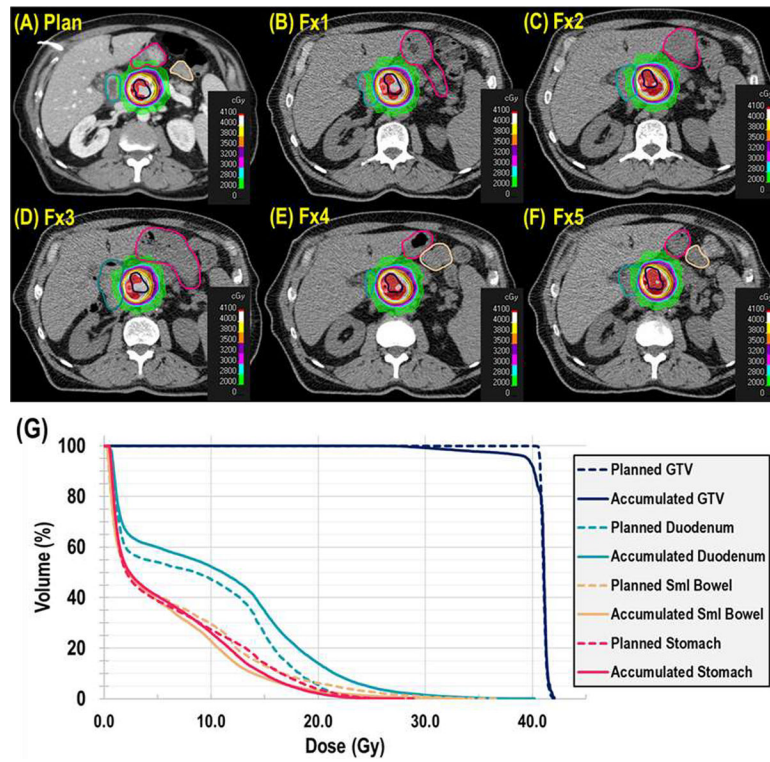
Anatomic variations affecting the dose distribution in a representative patient, with comparison of planned dose (A) to each fractional (Fx) dose (B–F). Each axial CT image is shown at the respective treatment isocenter, with the duodenum (teal), small bowel (beige), stomach (red) and gross tumor volume (GTV; dark blue) contours displayed with colorwashes of the treatment dose. (G) Dose-volume histogram comparison of the planned dose distributions (dashed lines) and the accumulated dose distributions (solid lines) for the duodenum (teal), small bowel (beige), stomach (red) and GTV (dark blue).
